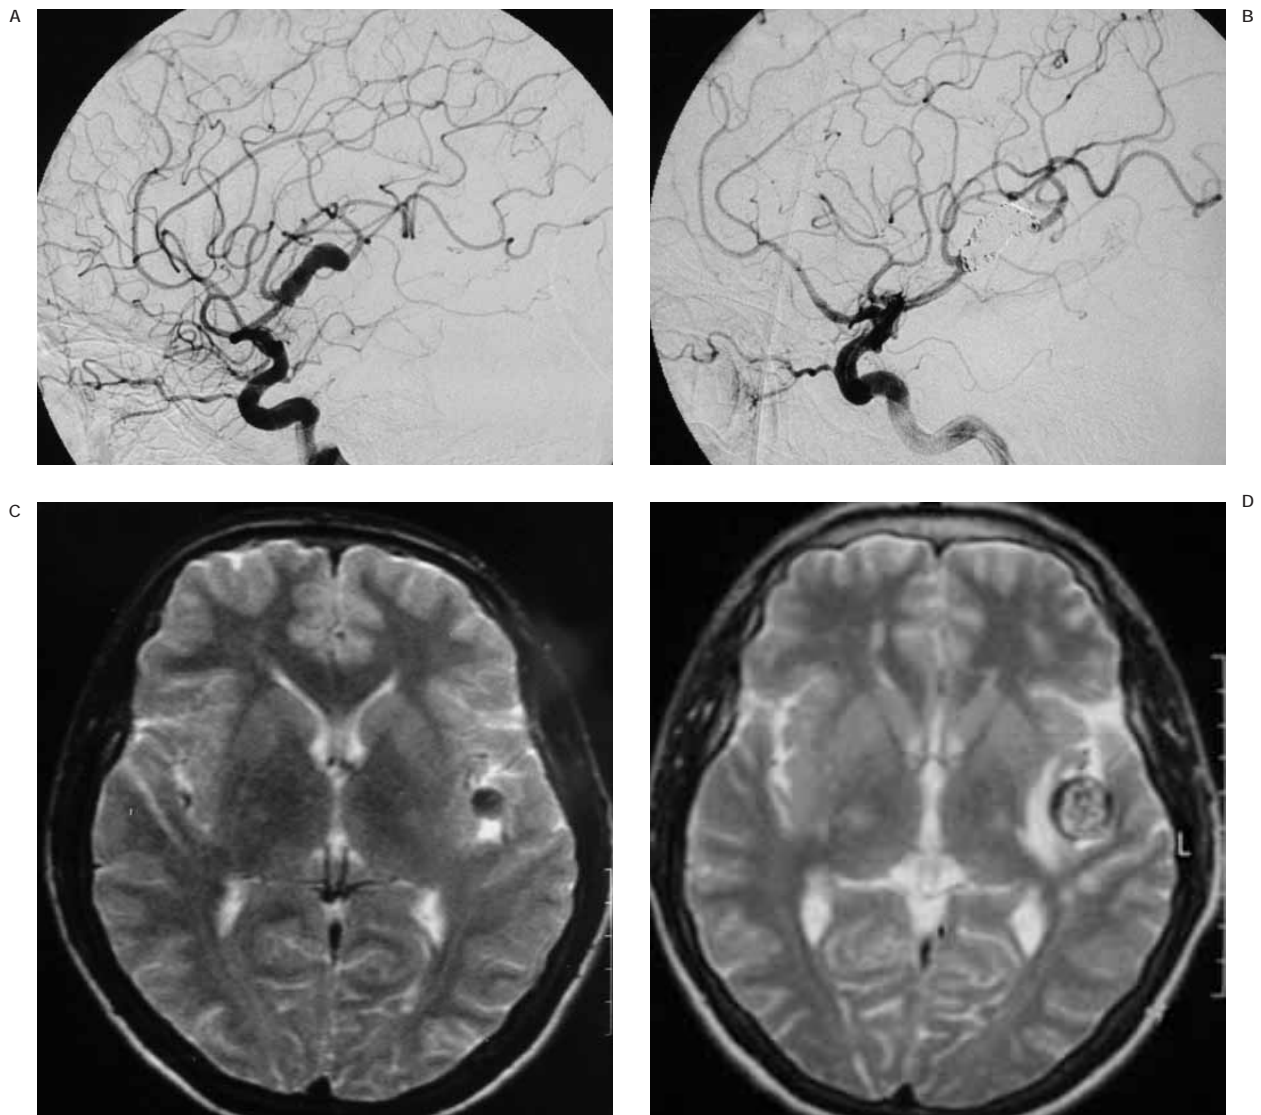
37-year-old man with a history of subarachnoid haemorrhage. A) Lateral left internal carotid arteriogram. Fusiform dilatation of angular artery branch of MCA is seen. B) Lateral postembolization view. Complete closure of the aneurysmal segment with end-to-end packing with coils. Note the antegrade filling of the artery distal to the aneurysm, that is expected to be thrombosed slowly. C,D) Pre- and postembolization T2-weighted axial MR images. The tiny hiperintensities indicating ischemic changes.
